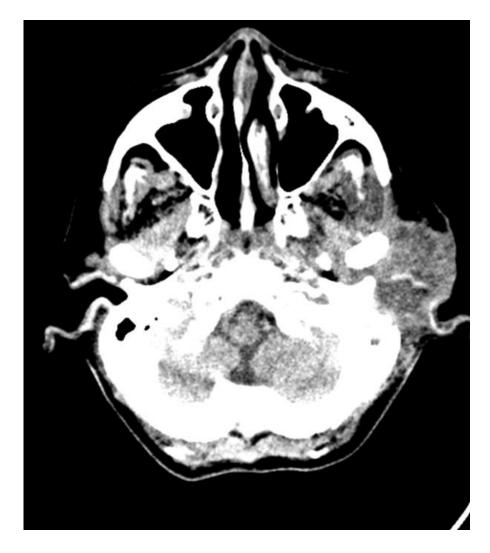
Axial non-contrast CT brain (another slice) scan.
